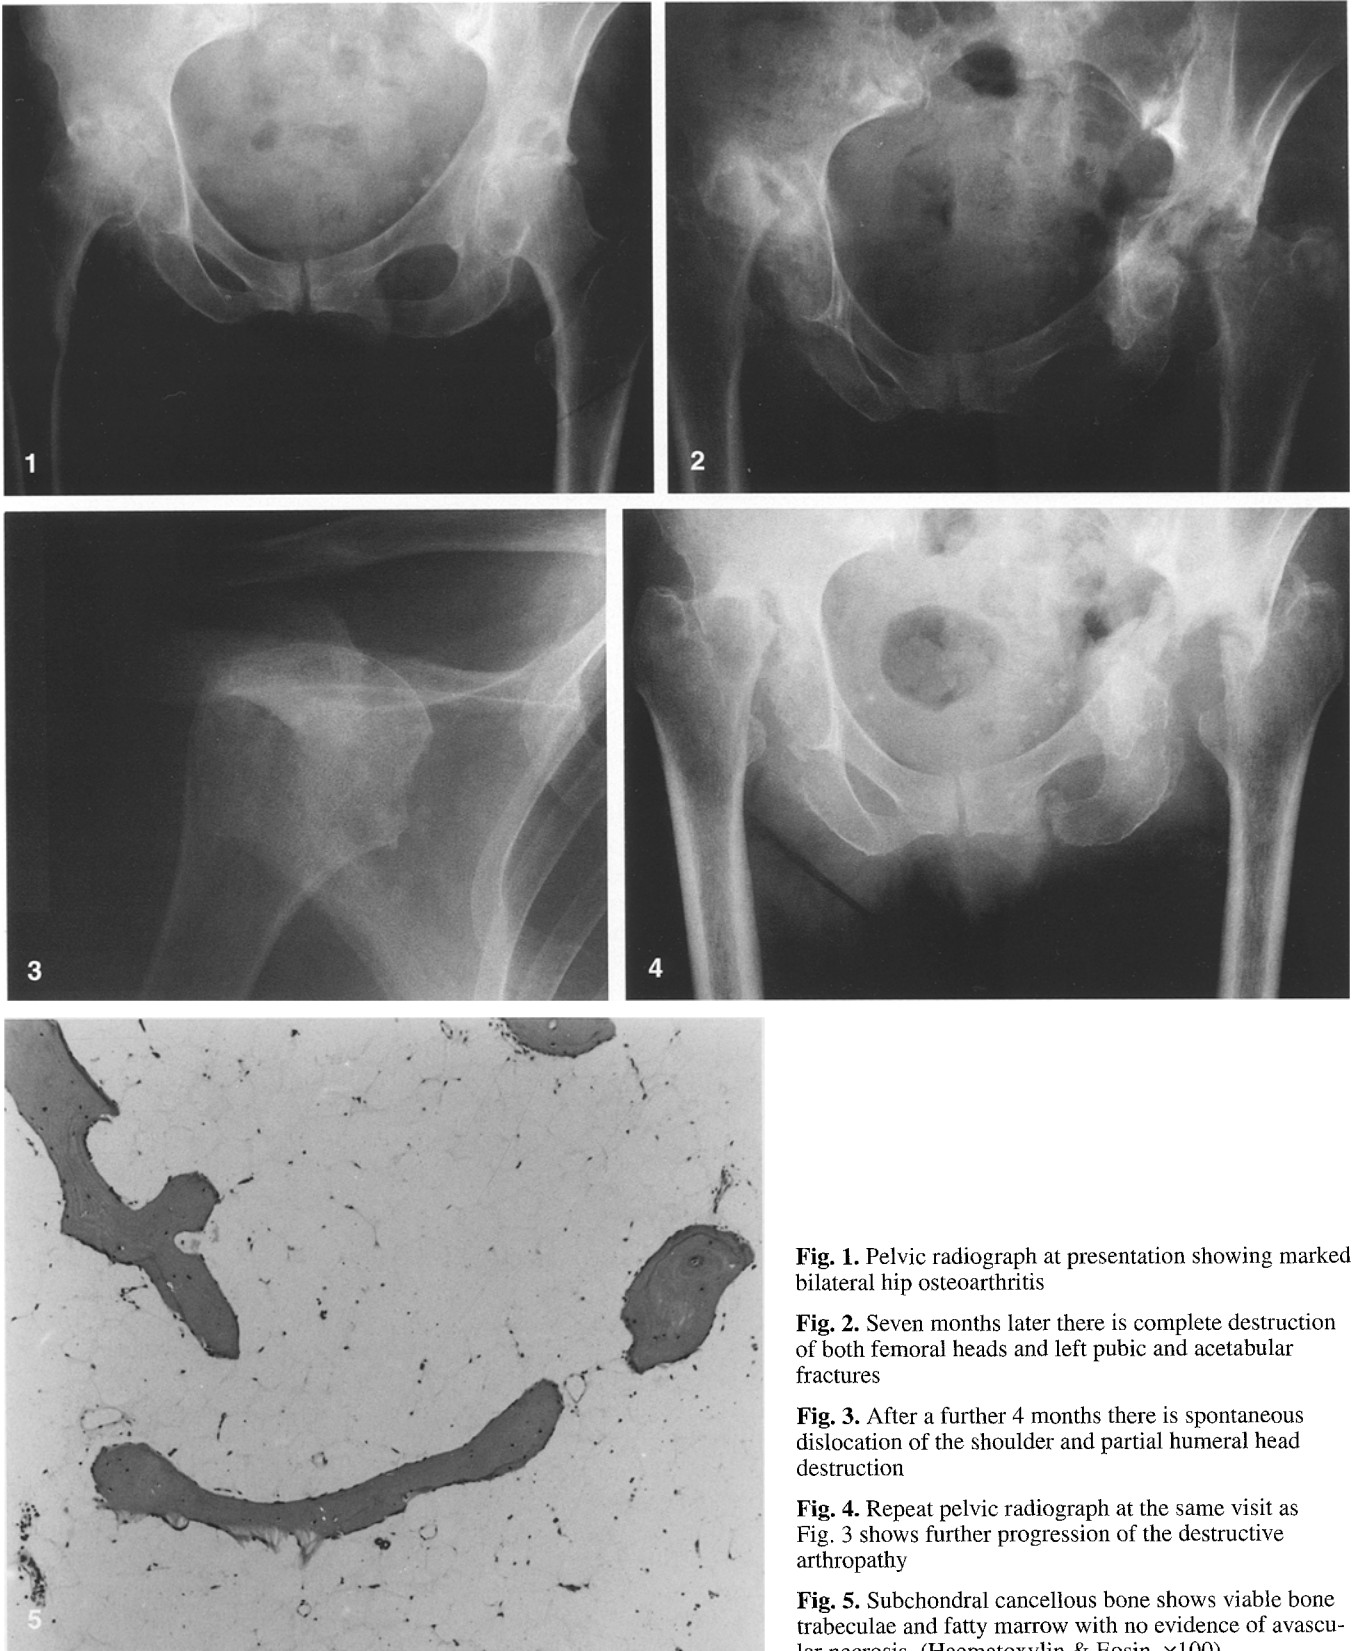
Pelvic radiograph at presentation showing marked bilateral hip osteoarthritis
